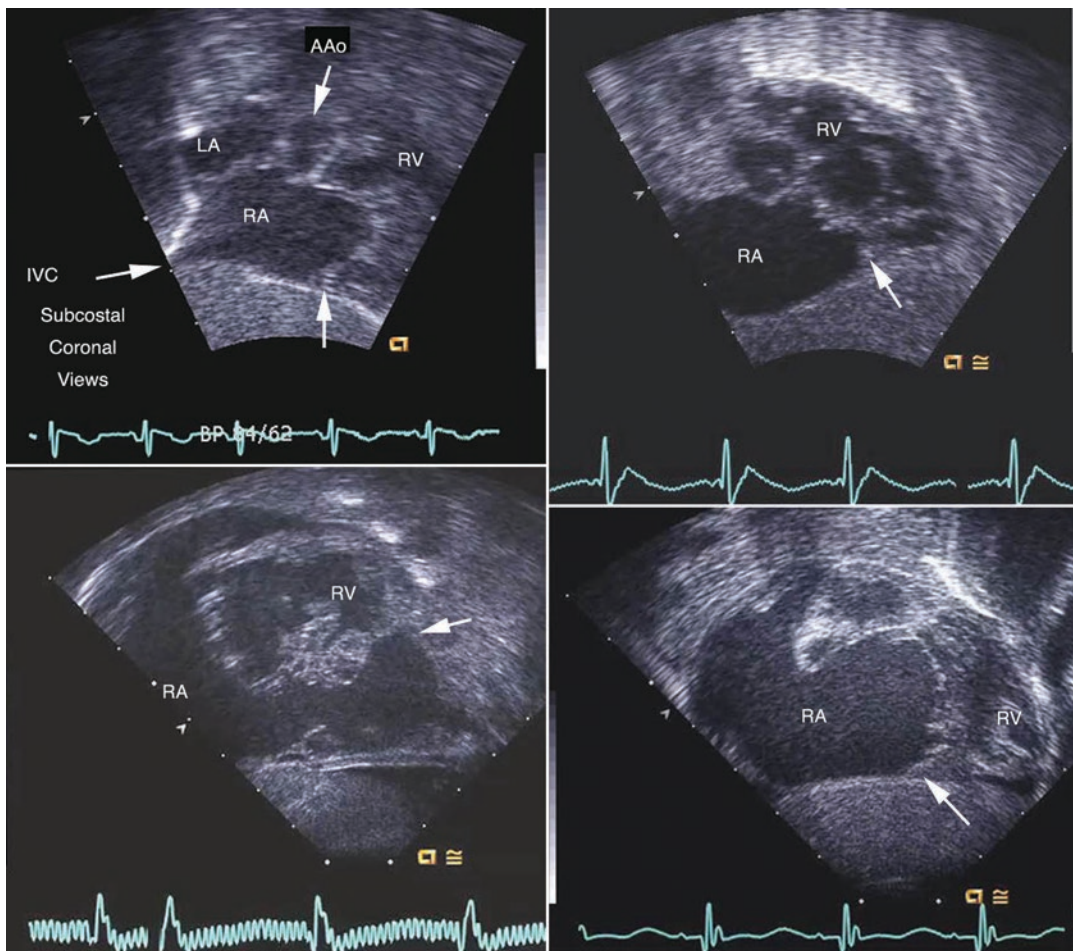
These subcostal coronal images demonstrate the same leaflet pathology as shown in Fig. 13.18 and indicate how echocardiography can fit into a surgical classification for treatment. The lesions are mild in the *top left frame*, more severe in the *top right frame*, worse in the *bottom left frame* and the worst in the *bottom right frame*.
